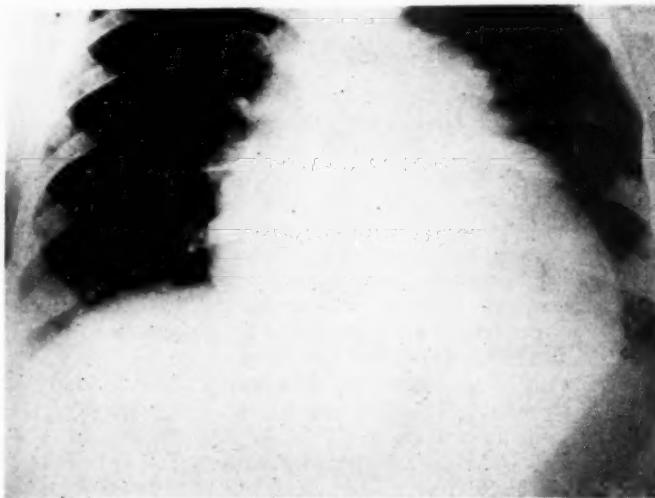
Roentgenogram of chest of Patient 4 shows gross pulmonary dilatation, absence of the aortic knob, and enlargement of the cardiac shadow.
